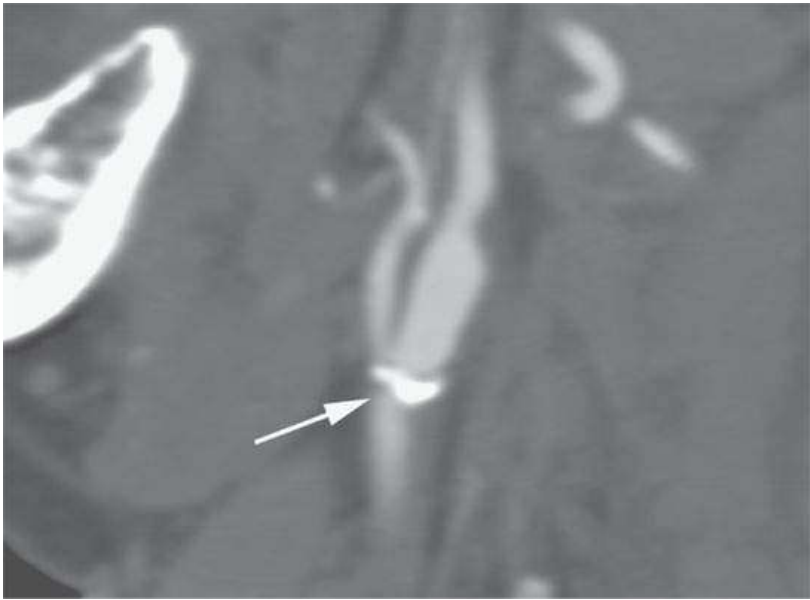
Computed tomography of a carotid bifurcation calcification (*arrow*), showing an obvious strength of computed tomographic angiography over magnetic resonance angiography and vascular ultrasound.
